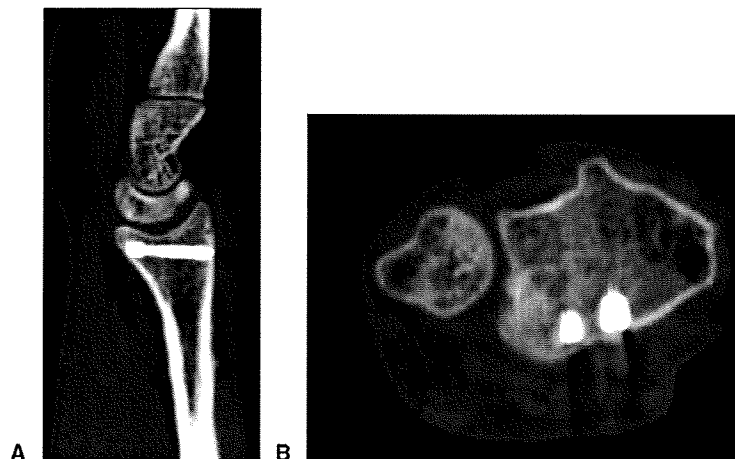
A, B Computed tomography shows congruity of the radiocarpal joint and complete obliteration of the step-off.
